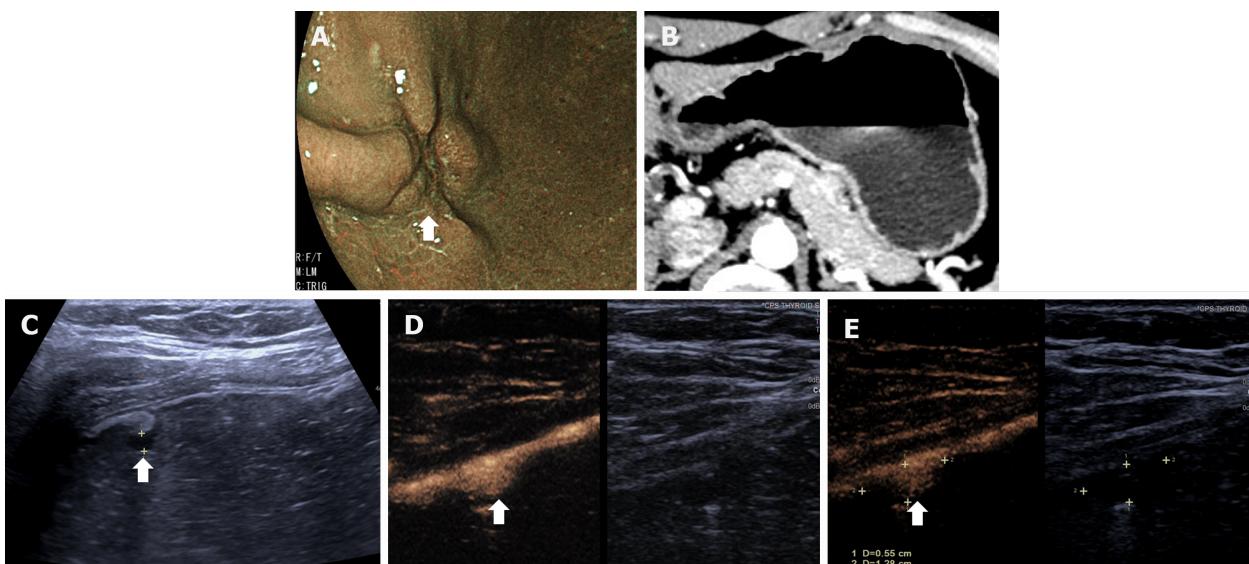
Images of T1a gastric cancer in a 52-year-old woman. A: Gastroscopic image shows a malignant ulcer (arrow) with converging folds and uneven margin; B: Multi-detector computed tomography image shows the gastric wall with no tumor; C: US image shows the hypoechoic lesion (arrow) with the focal thickened mucosa; D: In the arterial phase, focal thickening of the mucosa is visualized. The lesion shows slightly delayed hyper-enhancement, similar to the submucosal layer; E: In the venous phase, the lesion shows hypo-enhancement compared to the submucosal layer. The submucosal layer consistently shows hyper-enhancement and is continuous and intact. The muscular layer shows linear hyper-enhancement, and is continuous and intact.
